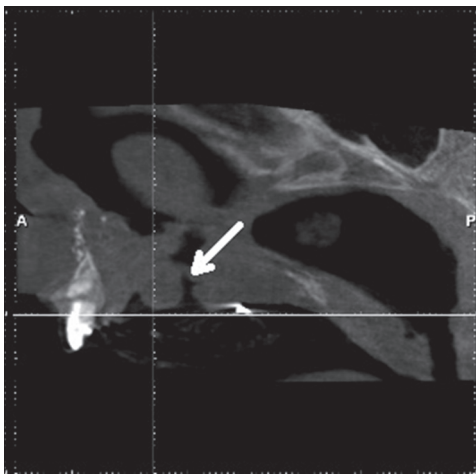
Postoperative cone beam sagittal computed tomography after 3 months demonstrating a cul-de-sac depression (white arrow)
